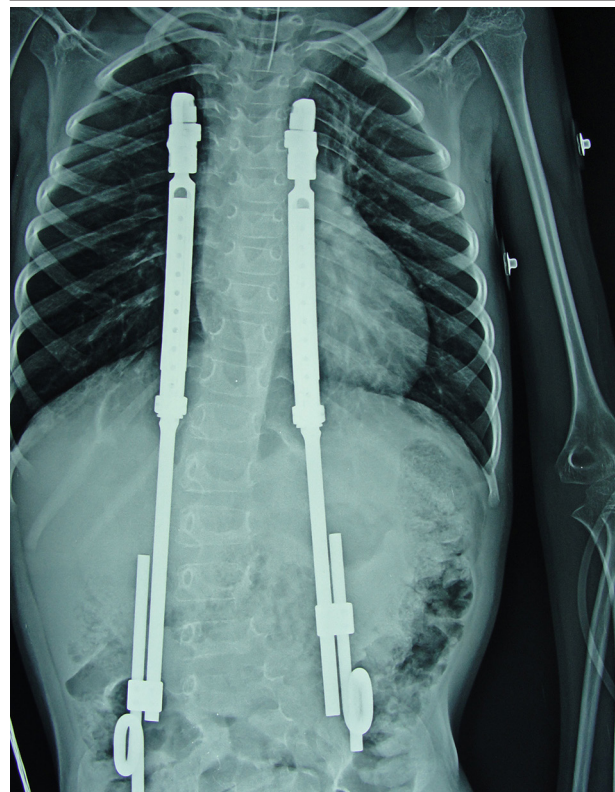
AP Radiograph 8-Year-Old Boy Patient With None Ambulatory Myelomeningocele Status Post Bilateral Rib to Pelvis VEPTR
